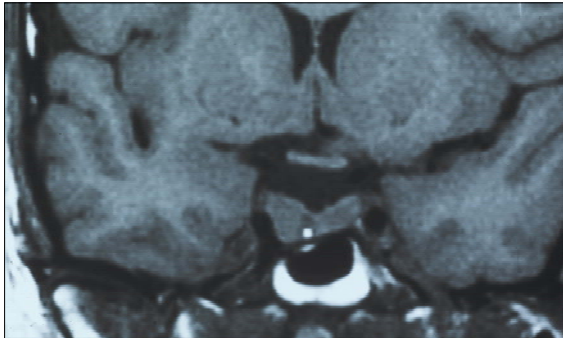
MRI scanning of the pituitary gland (no abnormalities)
